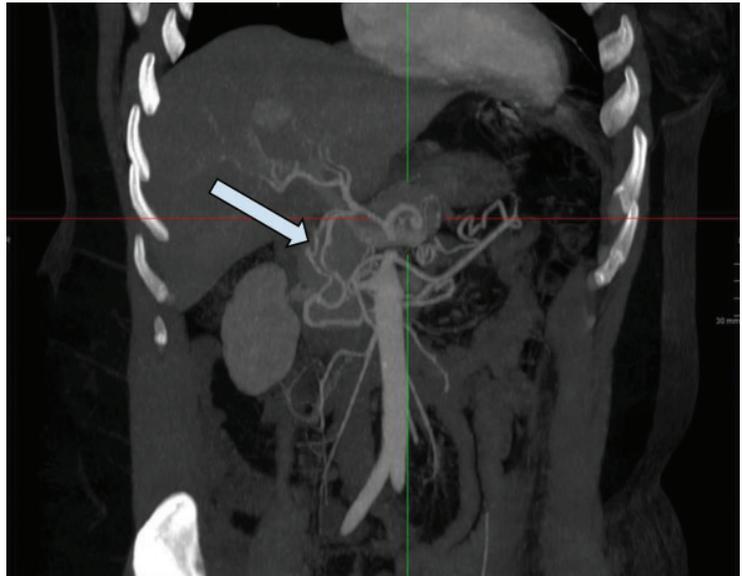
Contrast-enhanced computed tomographic angiography showed prominent poststenotic arterial collaterals in the peripancreatic region (arrow), with prominence of the gastroduodenal artery related to contribution to the celiac distribution from the superior mesenteric artery, which indicates the stenosis is chronic and hemodynamically significant.
